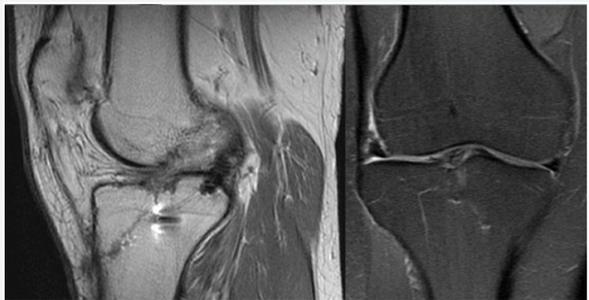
MR images showing normal alterations: the sagittal image on the left, enhanced in T1, shows artifacts of magnetic susceptibility by surgery at the level of the tibial epiphysis in relation to the anchor point and diffuse alterations of the signal at the level of the joint space. In the coronal image of the right, enhanced in DP with fat suppression, an extrusion of the transplanted meniscus body towards the external interline was observed.
